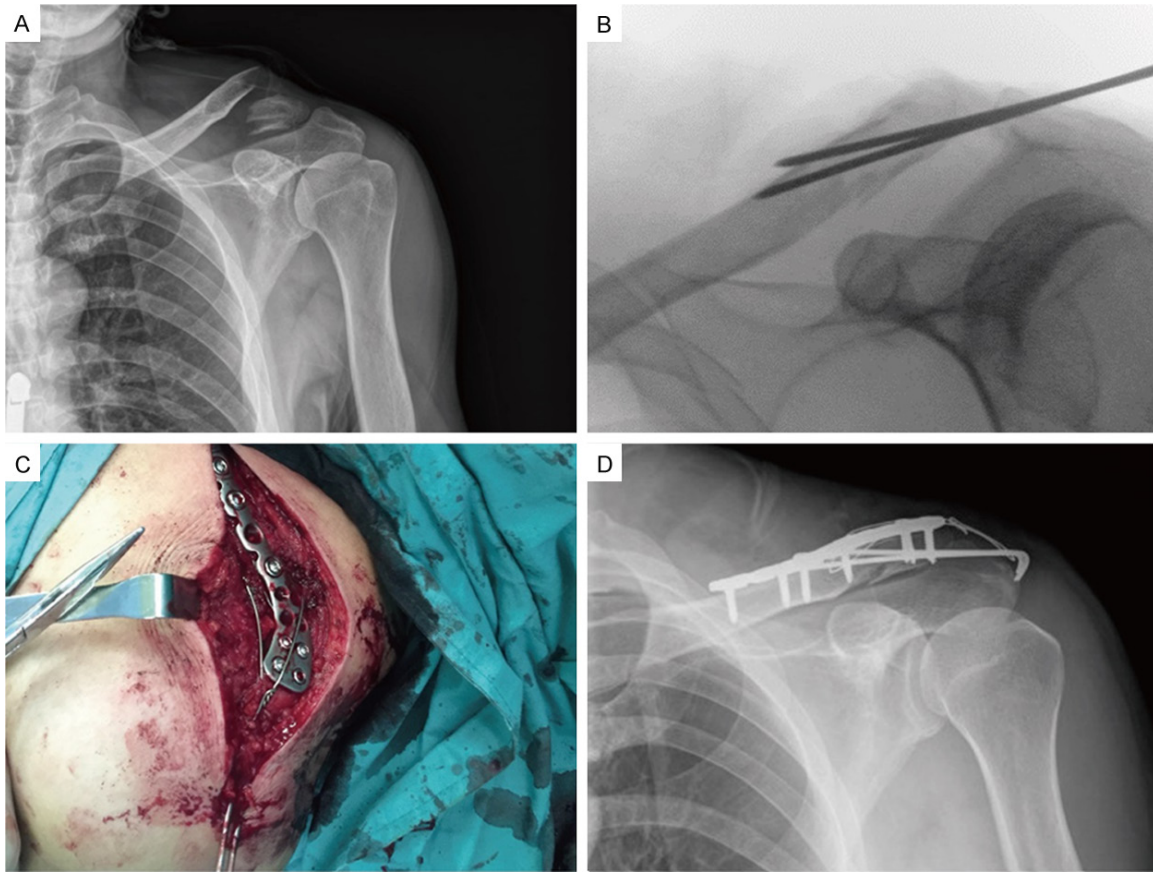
The operation technique: A. Radiograph after injury. B. Radiograph in operation. Two Kirschner wires were inserted in parallel from the outer margin of the acromion, penetrating the acromioclavicular joint and the fracture site to maintain the reset. C. After plate fixation, a steel wire was used in a figure of eight configuration. D. Radiograph after the operation.
